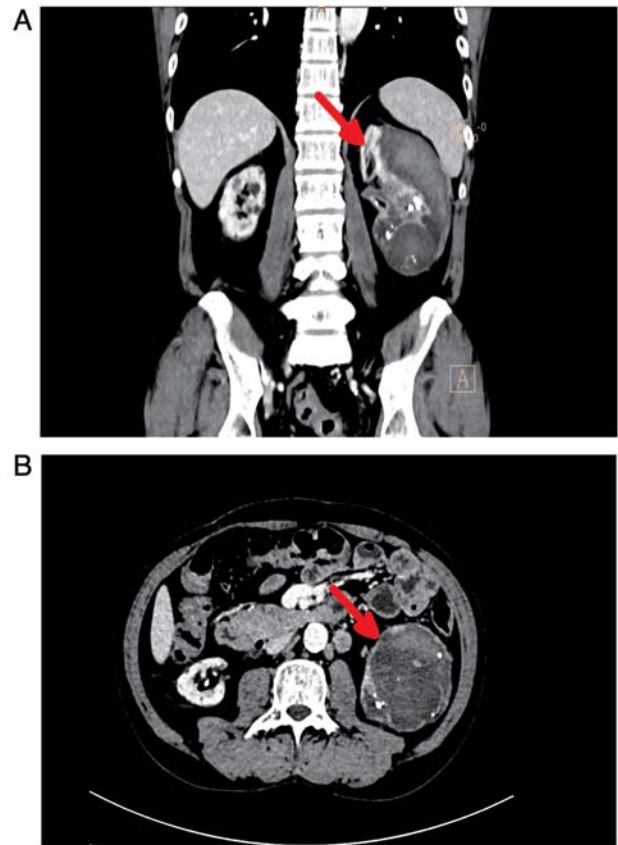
CT images. (A) Coronal and (B) axial planes demonstrate the mass as exhibiting mixed-density characteristics.
